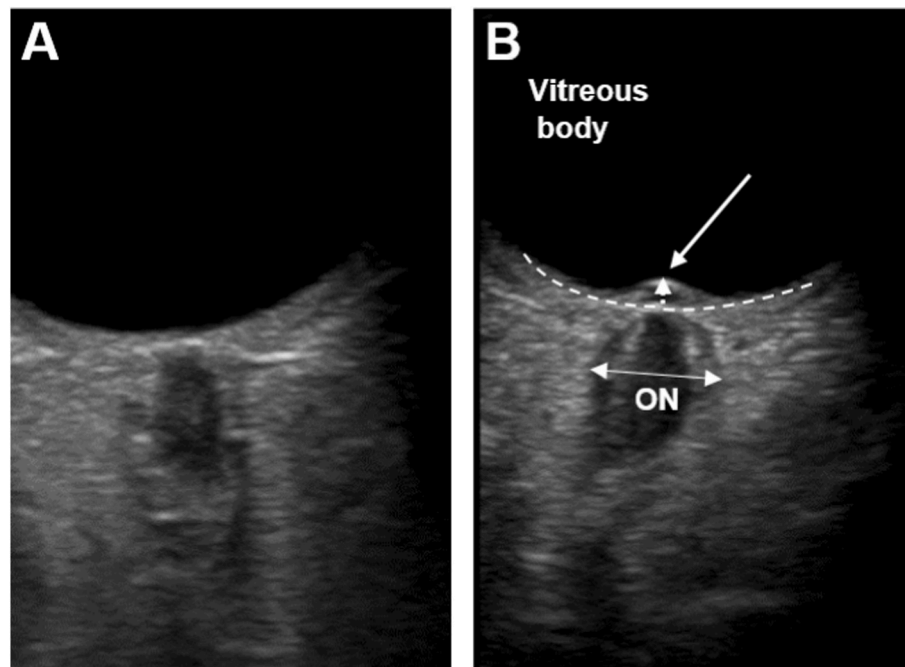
B-scan-ultrasound of the orbit A Transorbital US-image of a child without acute intracranial pathology with small values for US-ONSD and US-ODE. B Transorbital US-image of a child with acute intracranial pathology needing treatment. The optic nerve (ON) appears hypoechogenic and is surrounded by the hyperchogenic optic nerve sheath. The white double-arrow shows the region where US-ONSD is measured 3 mm behind the retina (dotted line). The white arrows show the elevated optic disc and the area where US-ODE is measured.
